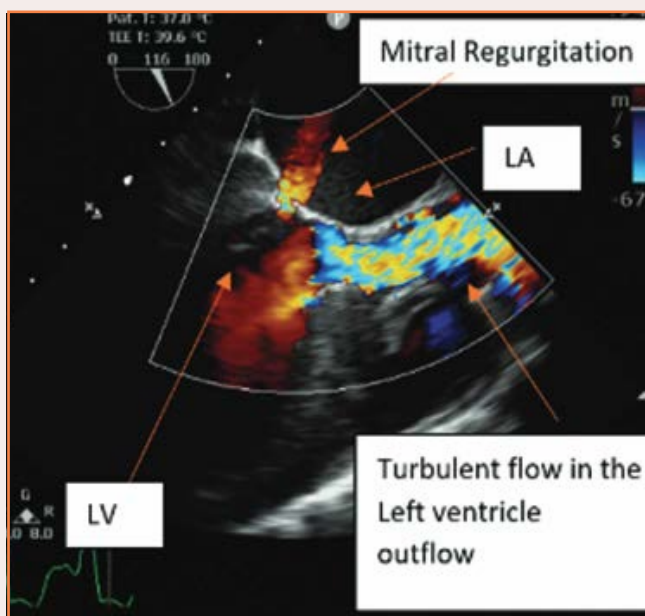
Turbulent flow in LVOT on colour doppler along with mild MR
